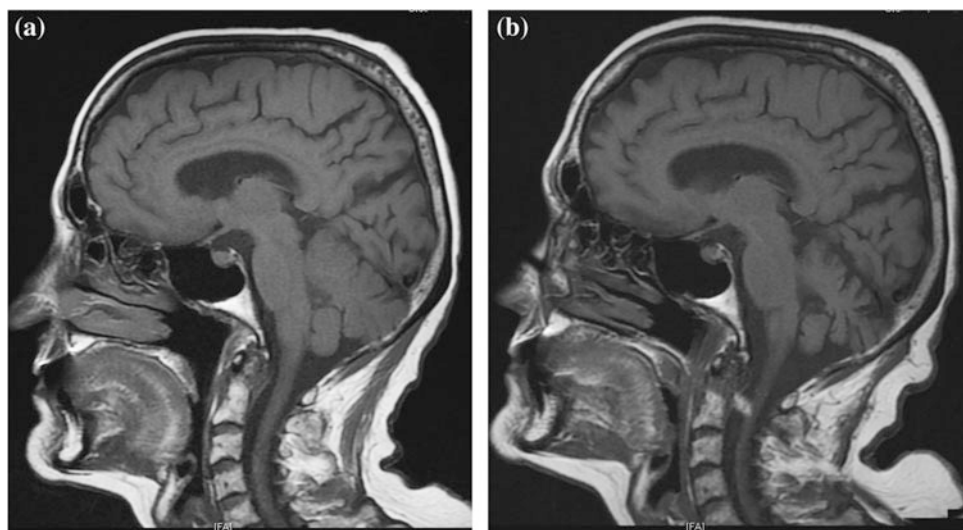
Paraneoplastic cerebellar degeneration. Sagittal T1-weighted images of a 71-year-old woman with FIGO stage IIIc ovarian cancer (a, b). Following surgery, the patient was treated with carboplatin and taxol and several months into therapy started having some difficulty with balance. She underwent brain MRI (a) which was unremarkable. She was tested for presence of paraneoplastic antibodies
